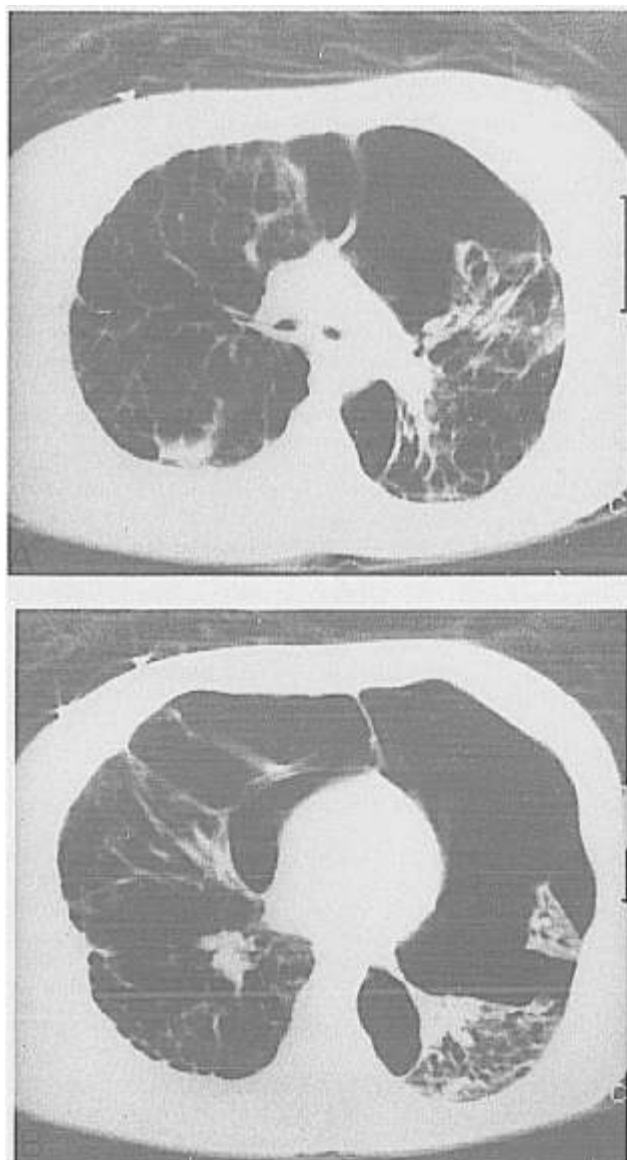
Chest CT scan taken before connection to bypass (at PEEP 0 cm H₂O). Presence of bilateral pneumothoraces and hyperinflation of the bullae, hilum (A), and base (B).
